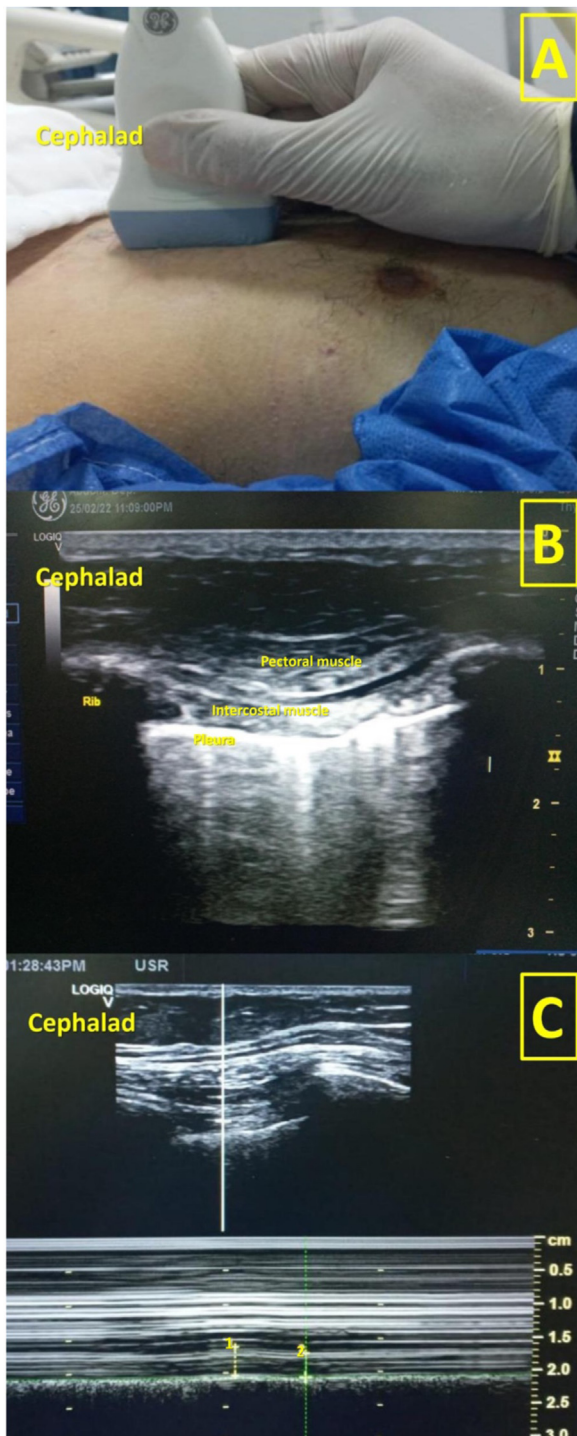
Ultrasound scan of the parasternal intercostal muscle. A: The transducer is placed vertically at the second intercostal space 3 cm lateral to the sternal border; B: Ultrasound image for the intercostal muscle; C: M-mode for assessing the cyclic respiratory changes in intercostal muscle, 1: intercostal muscle thickening at peak inspiration, 2: intercostal muscle thickening at end expiration.
